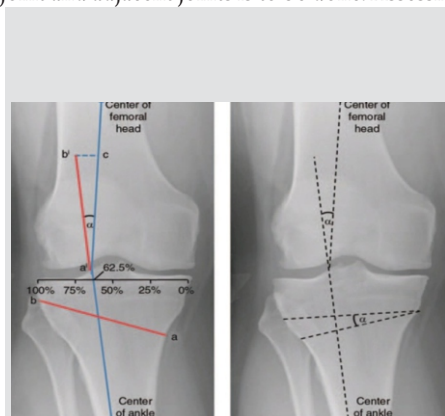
X-ray of Knee joint demonstrating the Fujisawa Point and planning for angle of medial open wedge.
